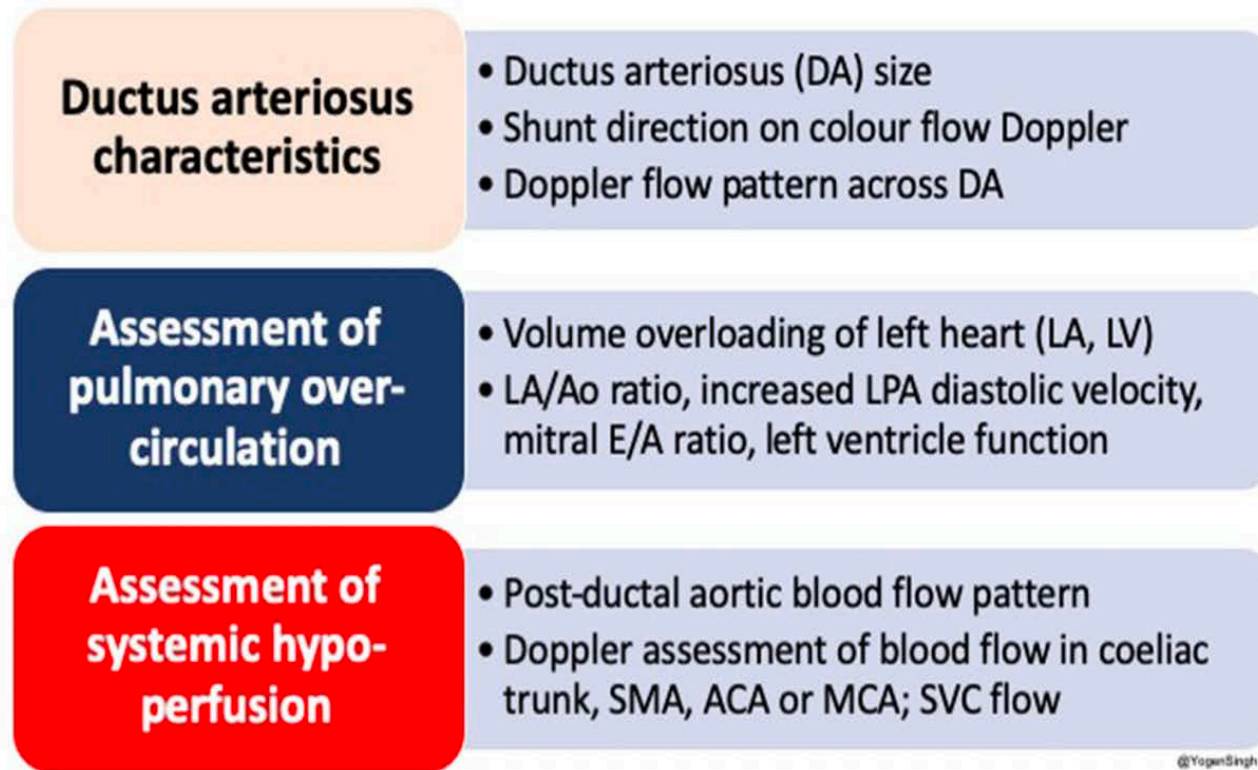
Summary of an approach to echocardiographic assessment of PDA and hemodynamic evaluation; LA, left atrium; LV, left ventricle; DA, ductus arteriosus; Ao, aorta; SMA, superior mesenteric artery; ACA, anterior cerebral artery; MCA, middle cerebral artery; SVC, superior vena cava.
